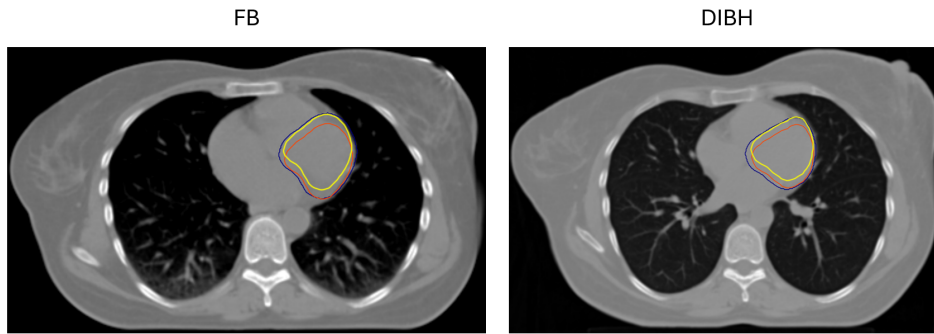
CT images display PRV contours associated with the LV in dark blue, alongside contours displaced towards the anterior (yellow) and posterior (orange).
